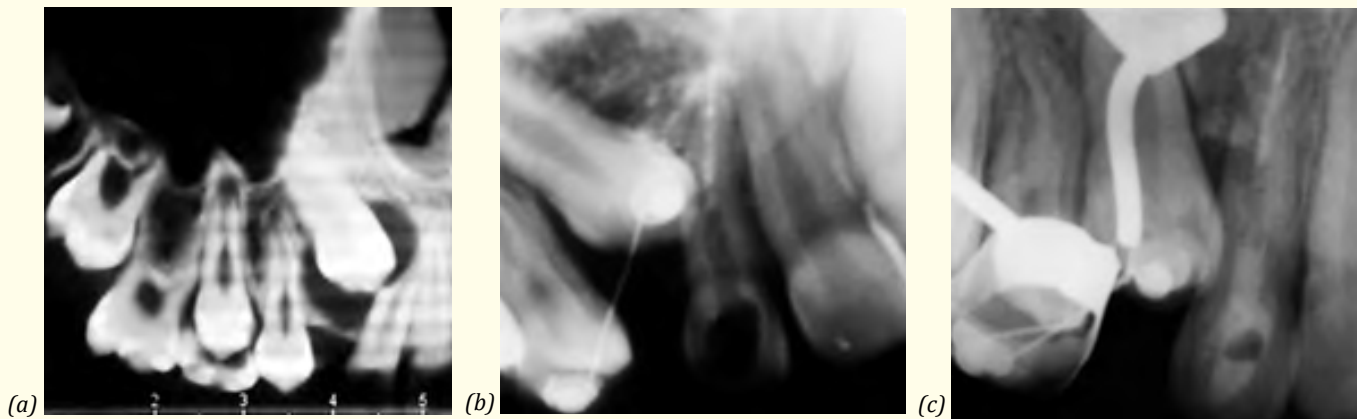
(a) Initial radiography. (b) Immediate postoperative radiography and. (c) X-ray of the control per year.
